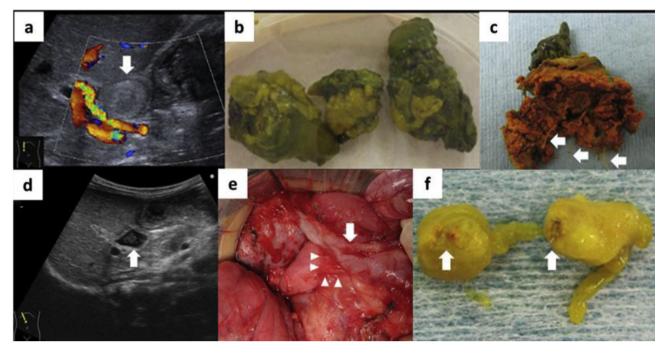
First stone formation demonstrated on ultrasound in the Roux-en-Y (RY) limb proximal to the porta hepatis (a). The egested stone was retrieved from the patient's feces (b). Its core was composed of suture thread (arrow) used for Kasai portoenterostomy (c). Ultrasound showed recurrent stone formation and pooling of bile in the same lesion (arrow) (d). The RY limb proximal to the porta hepatis had been kinked (arrow) due to adhesion (arrowhead) (e). The core of the stone was composed of surgical staples (arrow) used for the Kasai operation (f).
